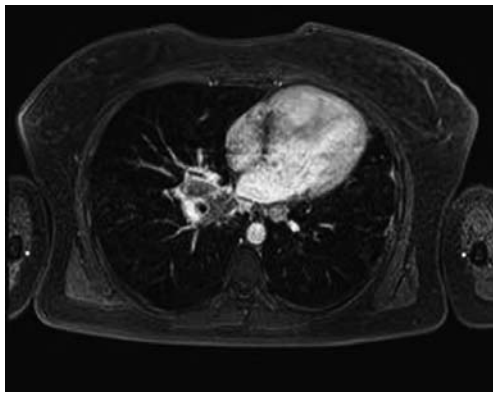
Coronal T1-weighted contrast-enhanced fat-suppressed image; abnormal hilar and mediastinal mass with contrast enhancement – narrowing of the inter-medium bronchus
